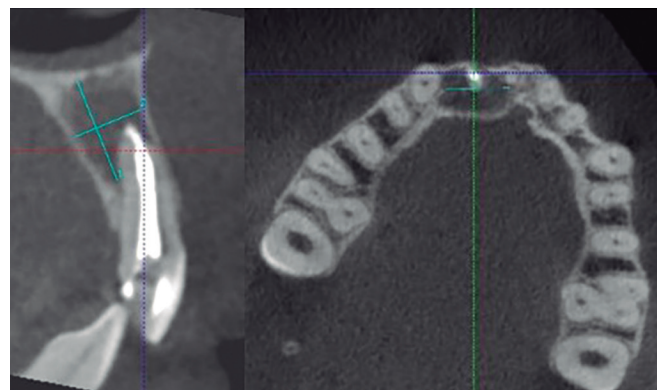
Initial cone beam tomography taken immediately after the first session. Lesion size of approximately 10 mm in the vertical and horizontal mesio-distal direction. Radiopaque intracanal material in sagittal view corresponds to Ultracal (Ultradent).
